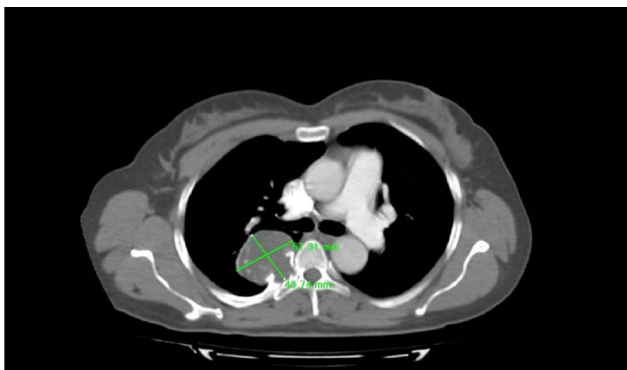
A thoracic axial plane computed tomography with contrast enhanced imaging (with mediastinal window) shows a heterogeneous mass at the right fifth–sixth costo-vertebral angle measuring 51–48 mm, 1 year preoperatively.
